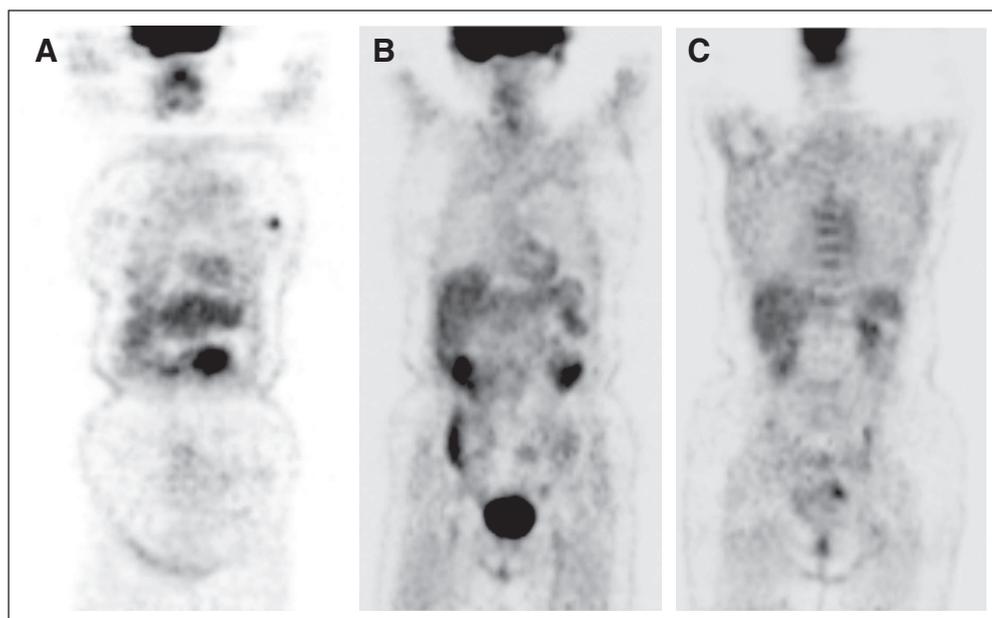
Fluorodeoxyglucose (FDG)-positron emission tomography images showing increased activity in primary tumor with no abnormal accumulation of FDG at axillae, bone, or other organs. Sentinel lymph node biopsy revealed a micrometastatic deposit.
